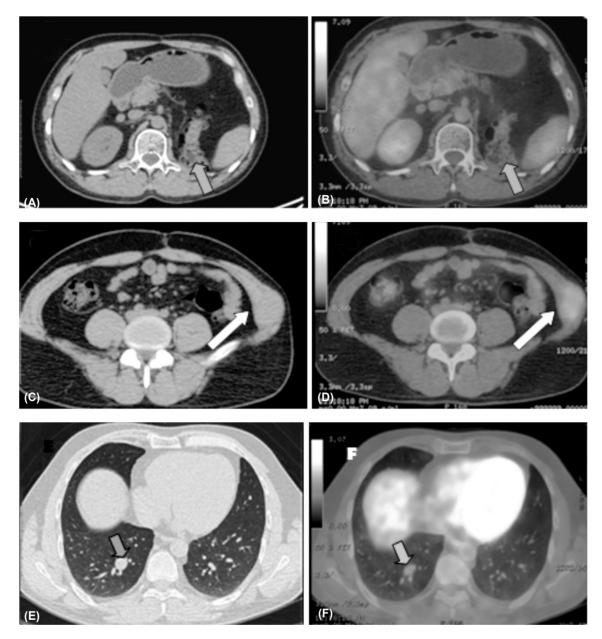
Axial CT and fused PET-CT images for a 45 year male patient with history of treated left renal cell carcinoma by left nephrectomy followed by chemotherapy.
